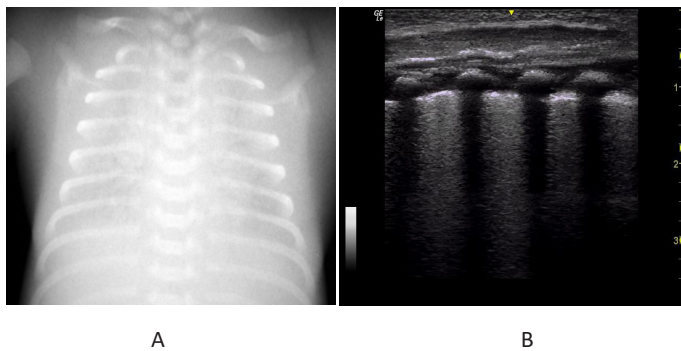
Newborn, gestational age 26 weeks. Respiratory distress syndrome of IV degree. A. X-ray reveals a “white lung”. B. Ultrasound shows an almost complete absence of pneumatization of the lung.
